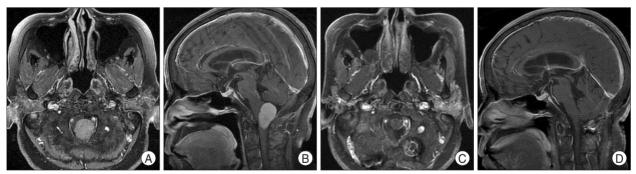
Pre- and postoperative radiological findings in posterior type foramen magnum meningioma. Preoperative MRI showed a 2×3 cm sized extra-axial homogenous enhancing mass in posterolateral portion of foramen magnum with displacement of cervical spinal cord, medulla anteriorly (A and B). There was no recurrence during 2 years after surgery (C and D).
